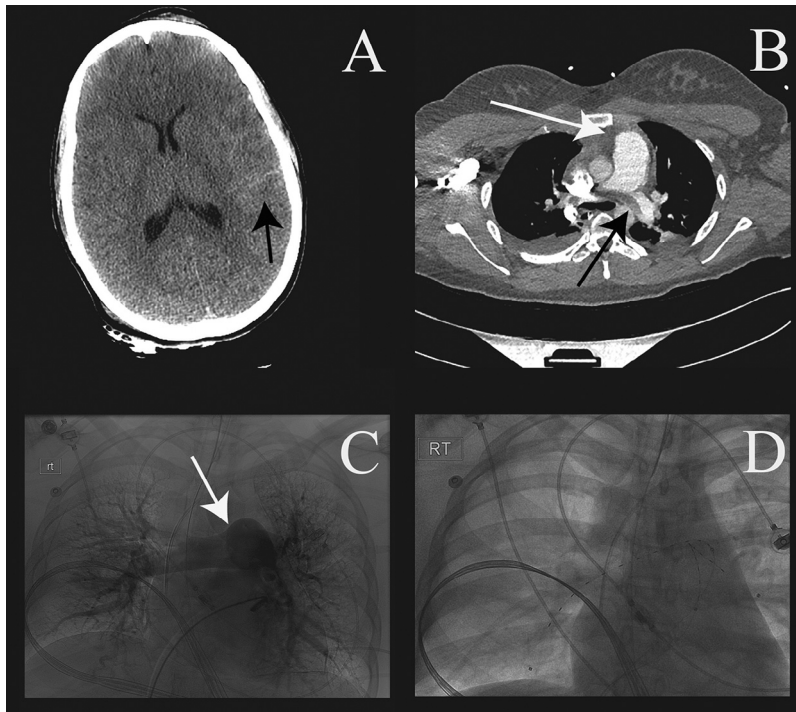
(A) Head CT showing left parietal-occipital intraparenchymal and left frontal-parietal subarachnoid hemorrhage. (B) Contrast-enhanced CTA of the chest showing large saddle embolus, RV/LV diameter ratio > 0.9, and enlargement of the main pulmonary artery. (C) Pulmonary angiogram showing large saddle embolus prior to EKOS catheter placement. (D) Fluoroscopic image showing placement of EKOS catheters in the bilateral pulmonary arteries. These were left in place for 12 hours infusing tPA at a rate of 0.5 mg/h in each catheter for a total dose of 12 mg/12 h. CT, computed tomography; CTA, computed tomography angiography; EKOS, Ekosonic Endovascular System; LV, left ventricular; RV, right ventricular; tPA, tissue plasminogen activator.
